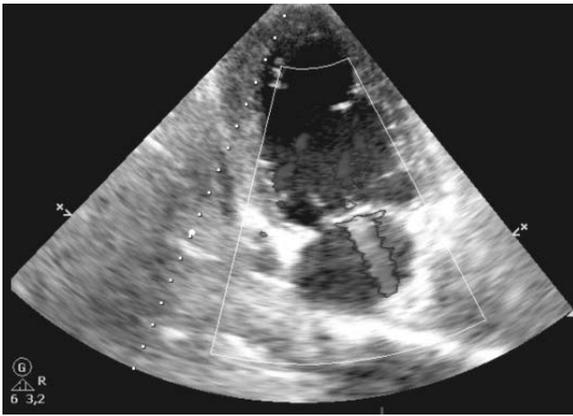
Parasternal long axis image obtained during transthoracic cardiac ultrasound showing dilated left ventricle and 3 on 4 mitral regurgitation.
